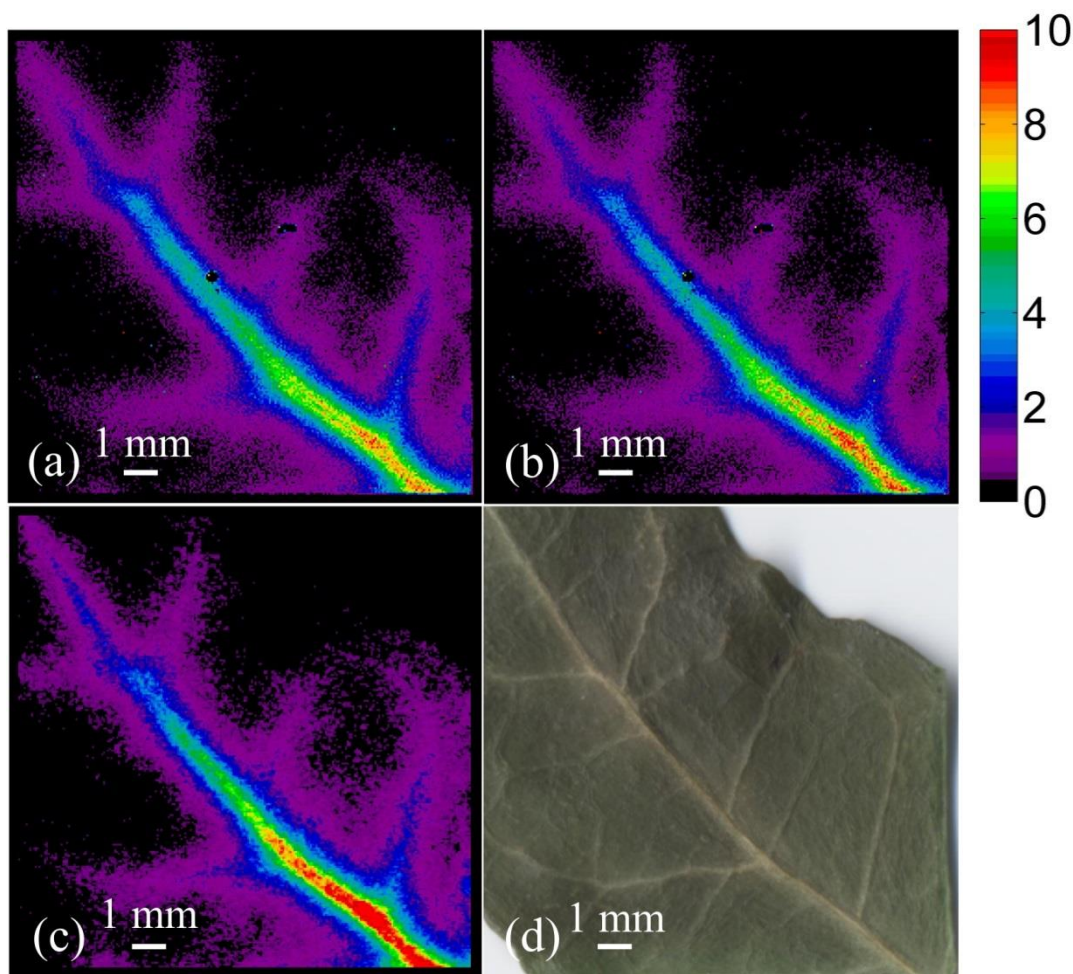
Imaging of the vein network of a leaf sample with $[^{18}\text{F}]$ FDG uptake. Figure (a) is the positron image applied with energy weighted centroid method applied; figure (b) is the positron image using classification method; figure (c) is the reference phosphor plate image; figure (d) is the optical image of the leaf sample. Figures (a) to (c) are normalized by the global mean and have the same amplitude display limits [0, 10].
